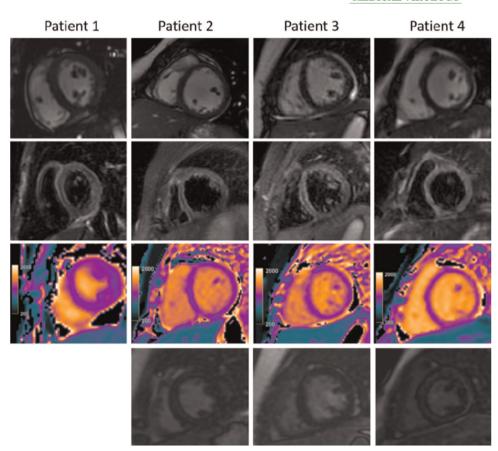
Cardiac MRI for four children with a clinical diagnosis of acute myocarditis in the setting of COVID-19-related Kawasaki-like symptoms. The top panel demonstrates minimal pericardial effusion on cine images. The second panel demonstrates increased T2-STIR signal intensity with average ratios between myocardium and muscle more than 2 in patient 2 (12-year-old male), patient 3 (11-year-old female), and patient 4 (6-year-old female). The third panel demonstrates abnormal native-T1 mapping, which was more than 1100 ms in patients 2, 3, and 4 and normal in patient 1 (8-year-old female). The bottom panel demonstrates absence of late gadolinium enhancement (LGE) in patients 2 and 3. Myocardial null times were recognized as too short in patient 4 but could not be repeated due to lack of further patient cooperation; however, a review of Look-Locker images and additional sequences revealed no LGE. Images obtained from Blondiaux et al. ¹⁸ Radiology, June 9, 2020, and permission to use granted by Ashley E. Daly, Senior Manager, Journal Rights & Communications Publications, Radiological Society of North America (RSNA). COVID-19, coronavirus disease 2019; MRI, magnetic resonance imaging
